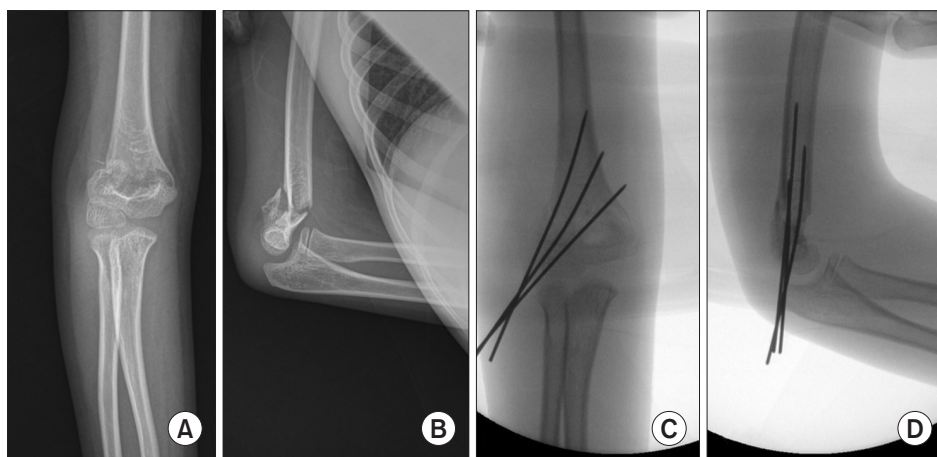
(A, B) Anteroposterior and lateral radiographs of the elbow showing a Gartland III supracondylar fracture in zone 2. (C, D) After satisfactory reduction in coronal and sagittal planes with fluoroscopy, the fracture was stabilized with two to three percutaneous 0.062-inch Kirschner (K)-wires. Generally, two K-wires are inserted laterally, with stability assessed by intraoperative fluoroscopy. A third wire was inserted laterally or medially if necessary to obtain stable fixation.
